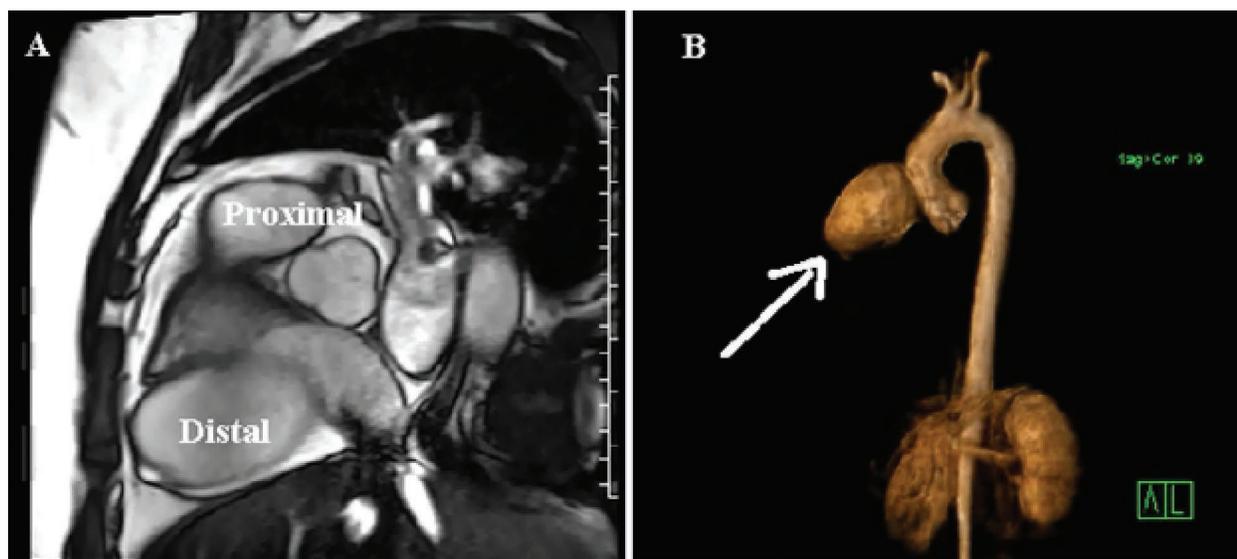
(A) Magnetic resonance imaging shows the proximal and distal aneurysm of the right coronary artery (RCA). (B) Cardiac computed tomographic scan (three-dimensional reconstruction) shows the aneurysmatic dilation of the RCA (arrow).
